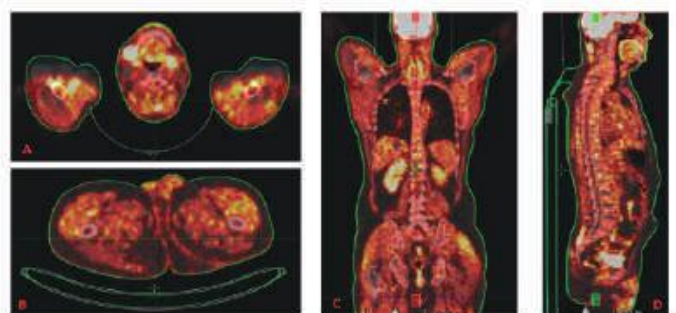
Post maintenance chemo PET-CT. A- metastases to right submandibular region, B- resolution of peri-anal abscess, C- Decrease in size of lung metastases.
